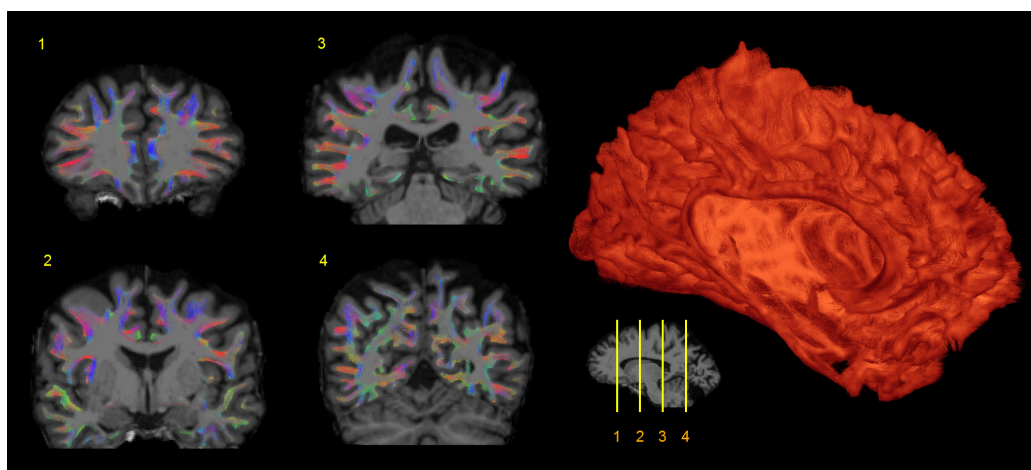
Final appearances of SAF tractograms following the filtering process. Left: SAF streamlines overlaid on the T1-weighted volume in dMRI space (coronal view). Right: 3D visualisation of SAF streamlines in one hemisphere (medial view). The sagittal slice at the bottom shows positions of the cuts on the left.
